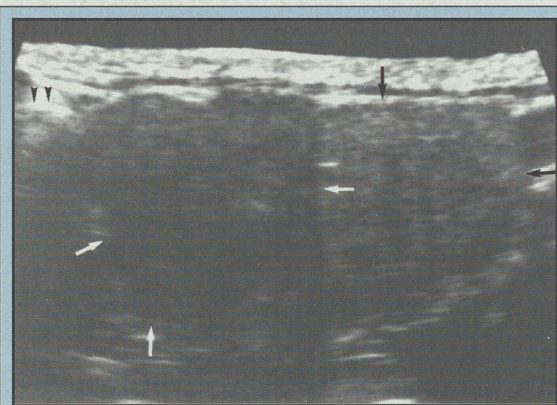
Longitudinal sonogram of the submandibular gland (black arrows) showing a solid, hypoechoic ill-defined malignant tumour (white arrows) of the submandibular gland. Arrowheads identify the mandible.
